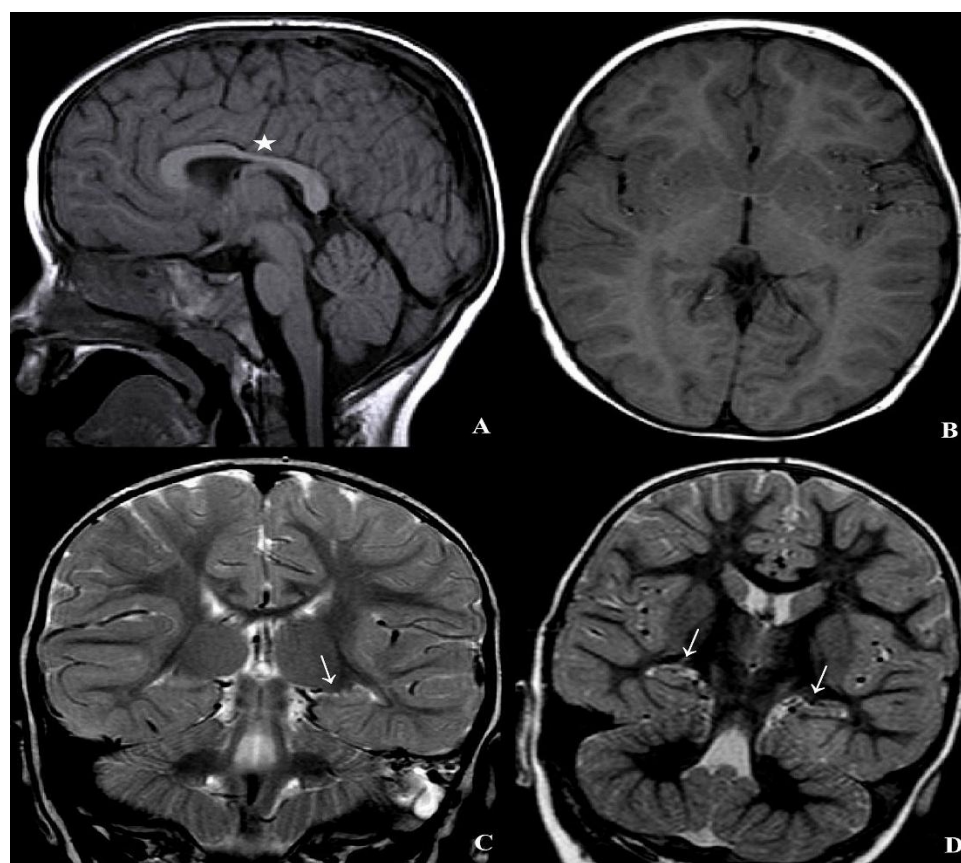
After two years of cobalamin supplementation, MRI images of the brain revealed that the supratentorial brain and corpus callosum (white star) had returned to normal volume (Panel A, sagittal T1 SE; Panel B, axial T1 SE). However, both hippocampi, particularly the left one, showed residual atrophy of the subicular and Ammon's horn regions (thin white arrows) (Panel C, coronal T2 SE; Panel D, coronal inversion recovery).
